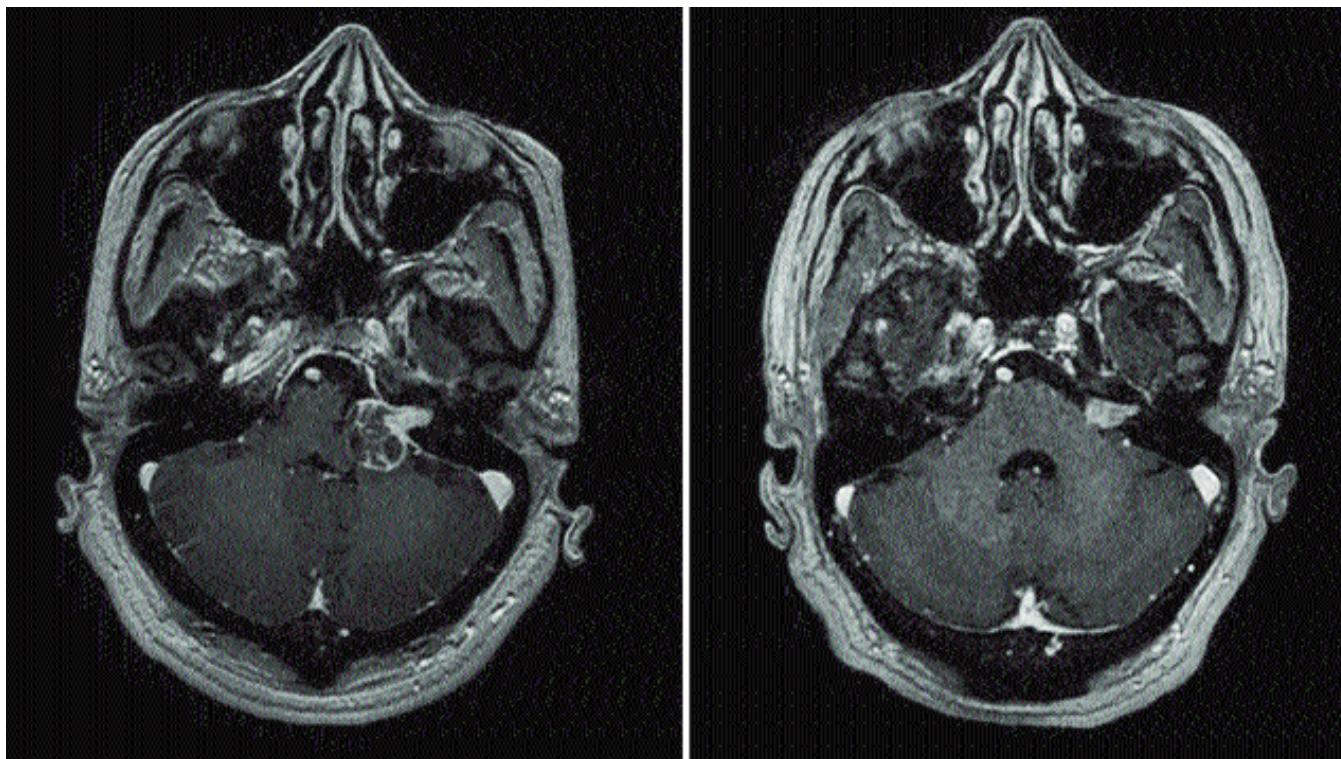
A patient's pre and post SRS MR images.
